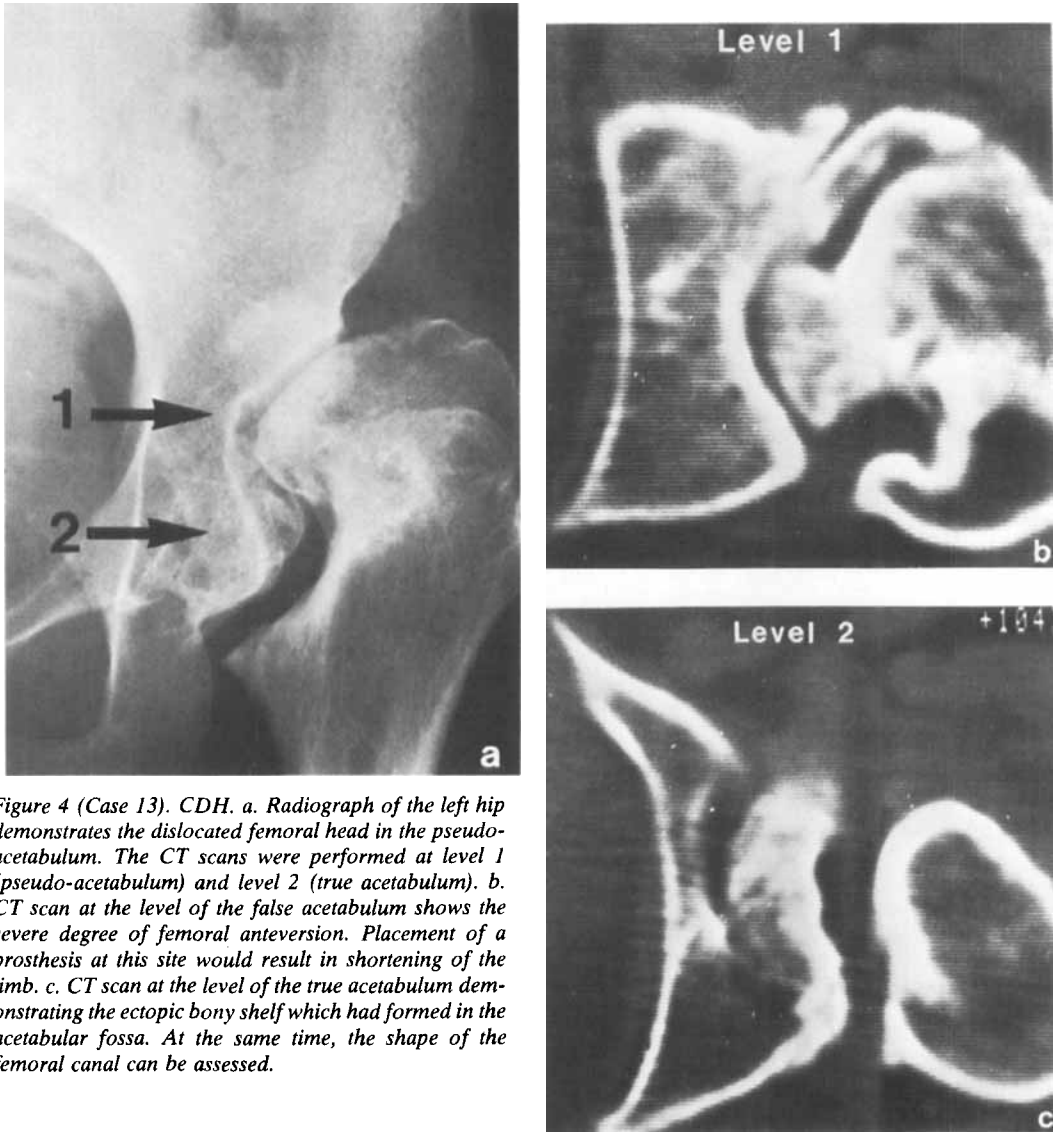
(Case 13). CDH. *a.* Radiograph of the left hip demonstrates the dislocated femoral head in the pseudo-acetabulum. The CT scans were performed at level 1 (pseudo-acetabulum) and level 2 (true acetabulum). *b.* CT scan at the level of the false acetabulum shows the severe degree of femoral anteversion. Placement of a prosthesis at this site would result in shortening of the limb. *c.* CT scan at the level of the true acetabulum demonstrating the ectopic bony shelf which had formed in the acetabular fossa. At the same time, the shape of the femoral canal can be assessed.
